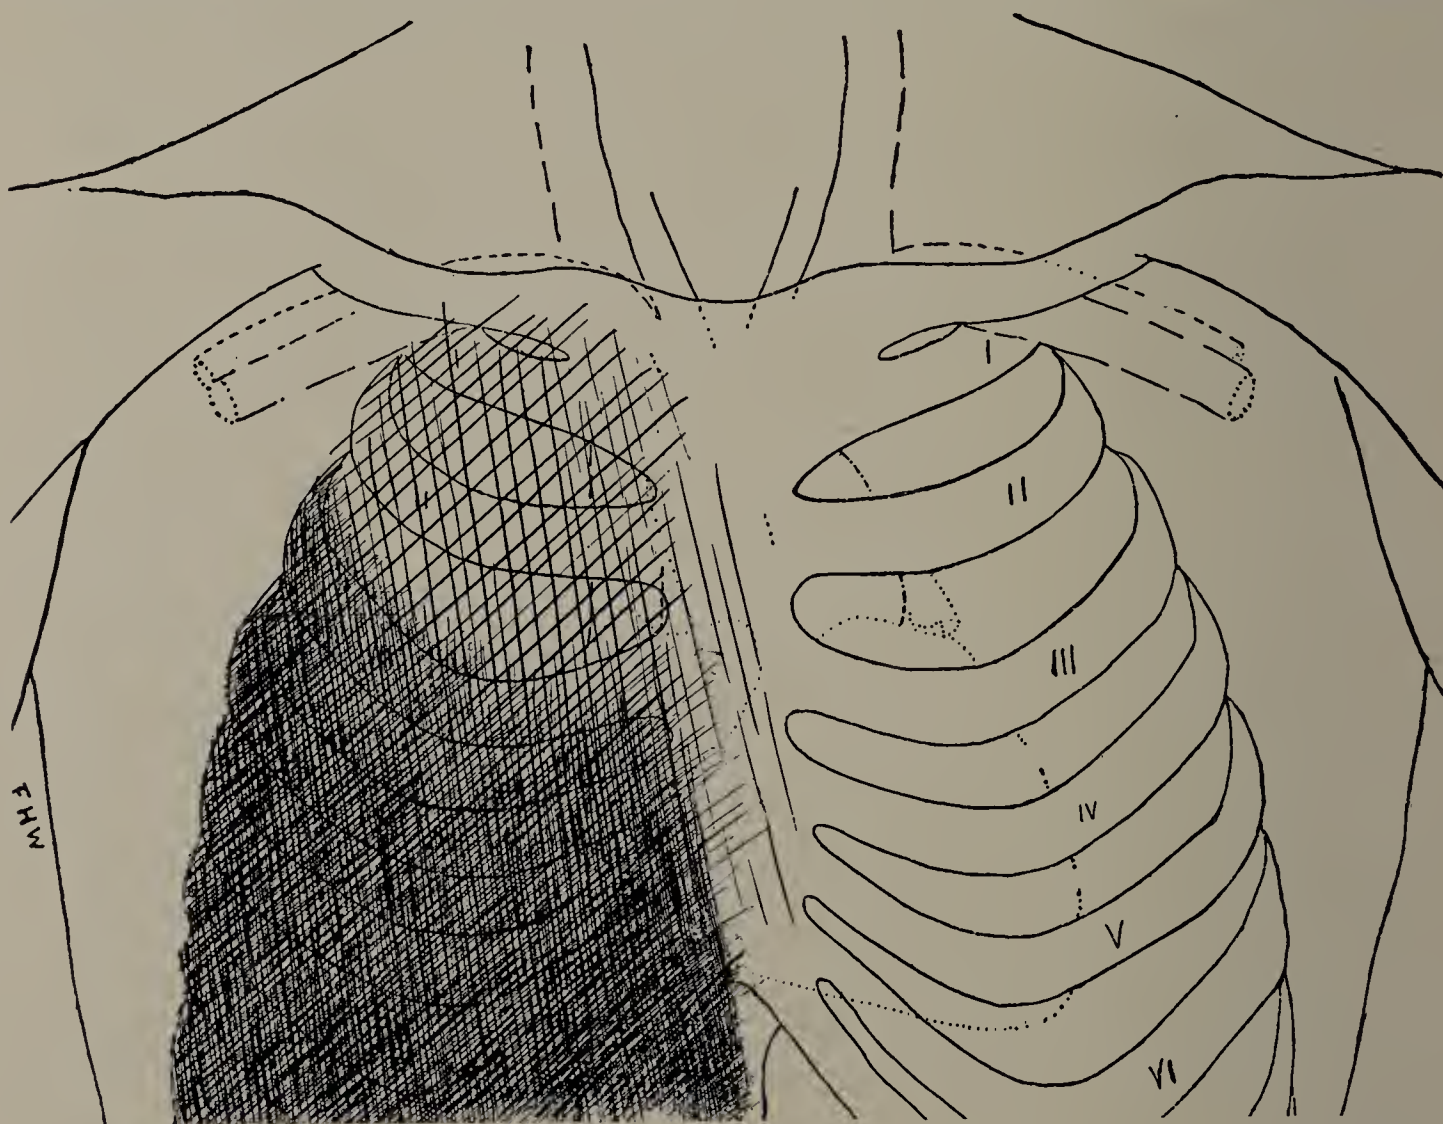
Patrick McM. Pleurisy with effusion. X-ray examination with screen. Darkened area on right side; no ribs and no outline of diaphragm could be seen on this side. Heart displaced to left (not shown in cut, nor are the diaphragm lines on the left side). (Cut one-third life size.)
